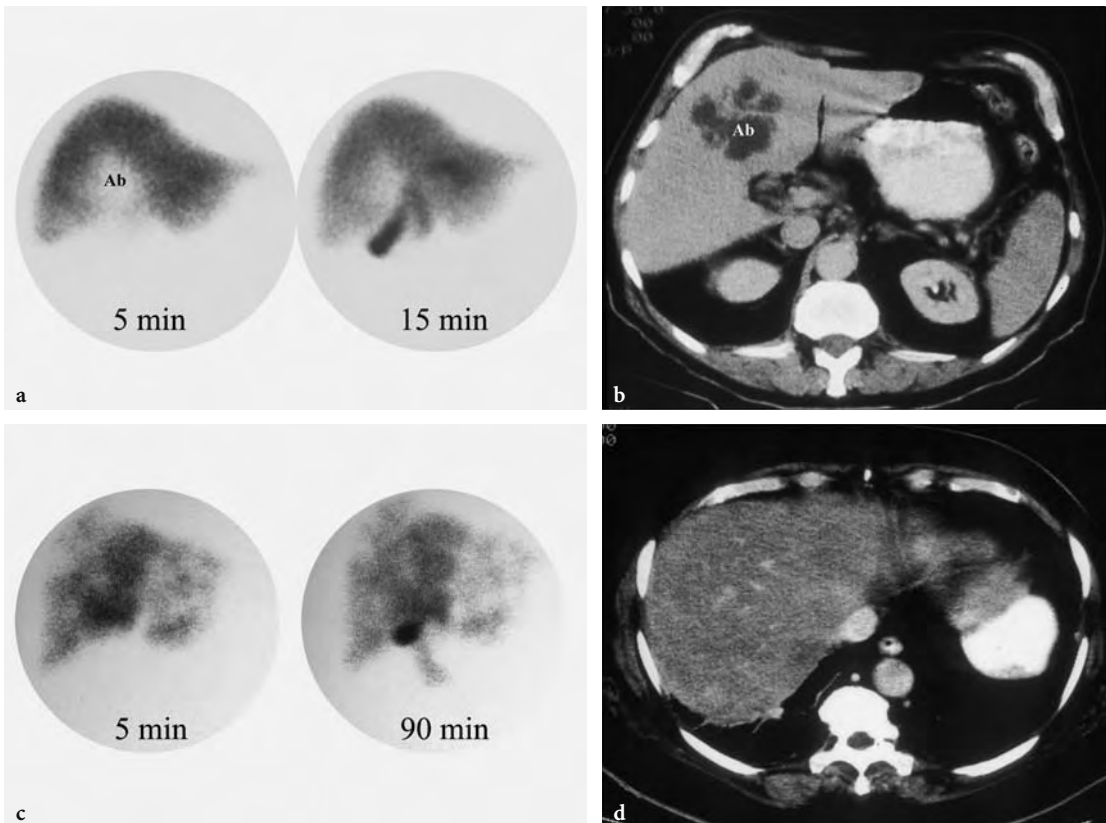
Two hepatocyte-replacing lesion patterns on hepatobiliary scintigraphy. a Anaerobic liver abscess exhibited as a solitary photopenic defect (*Ab*) on a representative hepatobiliary image at 5 and 15 min. Subsequent views (not shown here) also showed the defect, but with progressively decreasing clarity as the hepatic activity diminished. b A CT scan showed characteristic appearance of an abscess (*Ab*) corresponding to the photopenic defect. c A multifocal photopenic pattern is depicted on 5- and 90-min hepatobiliary images. d While the most common cause of such a finding is metastatic disease, in this unusual case the CT was most consistent with multifocal fatty replacement, which was subsequently confirmed by liver biopsy
